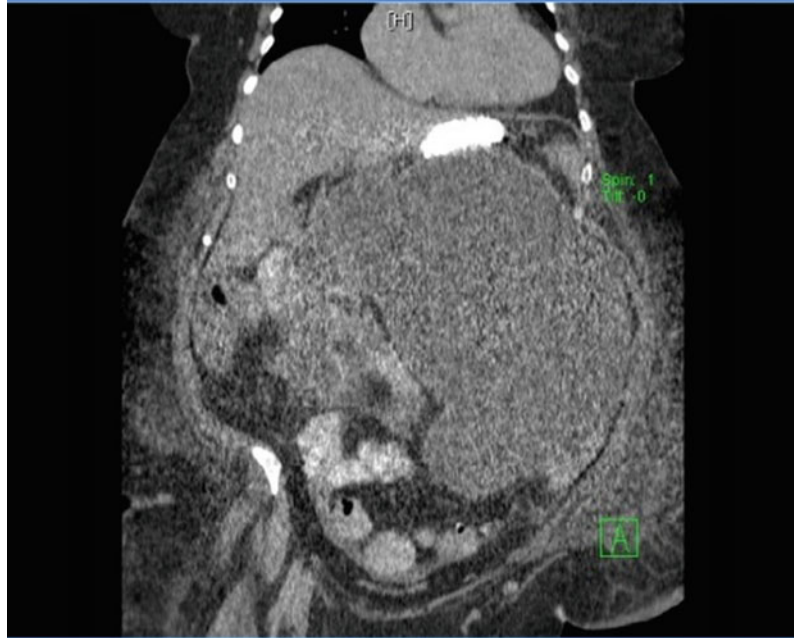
CT scan of a large pancreatic pseudocyst. The heterogeneity indicates the likelihood of necrotic debris
